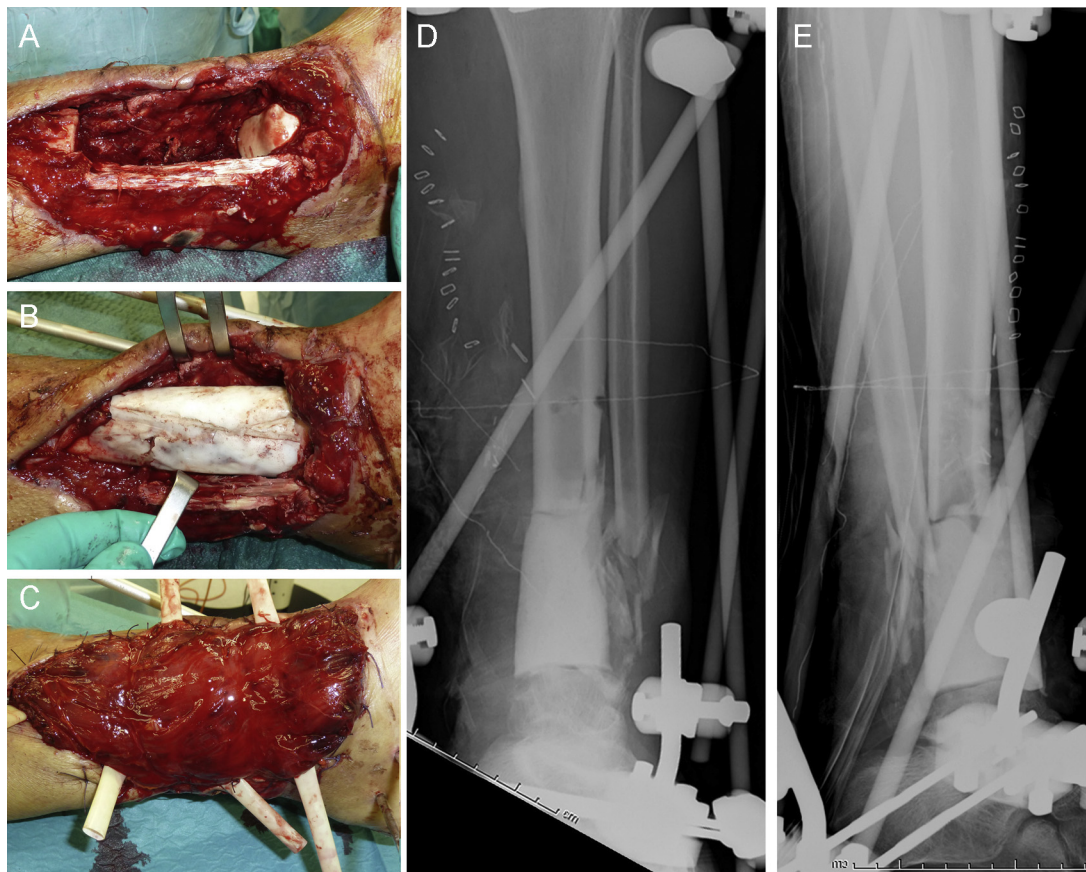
First step of the Masquelet technique. (A) Tibial bone defect sized about 6 cm after debridement. On the right side, the talar dome is visualised. (B) Customised cement spacer bridging tibia and talus. (C) Soft tissue coverage with gracilis free flap. (D and E) X-ray aspect of the cement spacer in antero-posterior (D) and lateral (E) view. Proper alignment and length of the limb obtained with external fixation.
